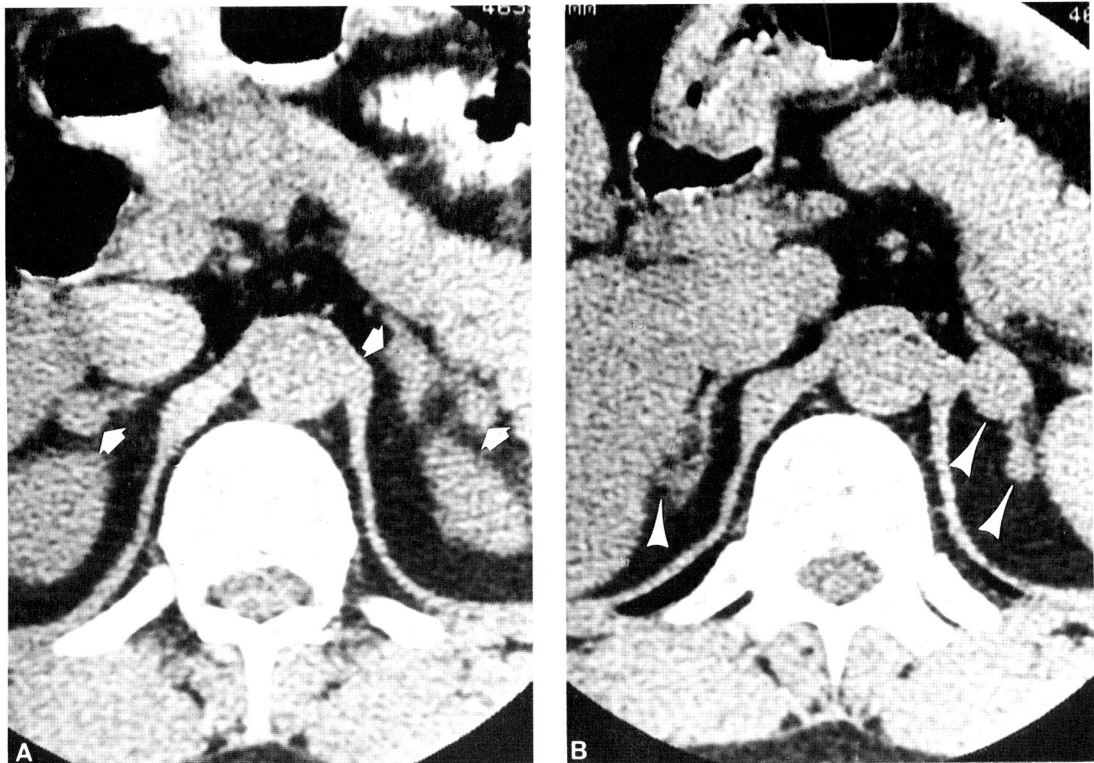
CT scan shows multiple adrenal masses arrows(Fig. 2A) and arrow heads(Fig. 2B) demonstrating isodensity with the liver noting in both adrenal glands.
